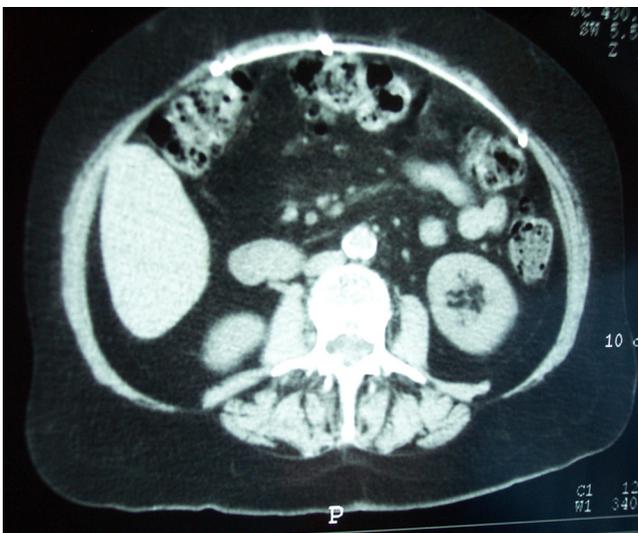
CT image of intra-peritoneal prosthesis.
